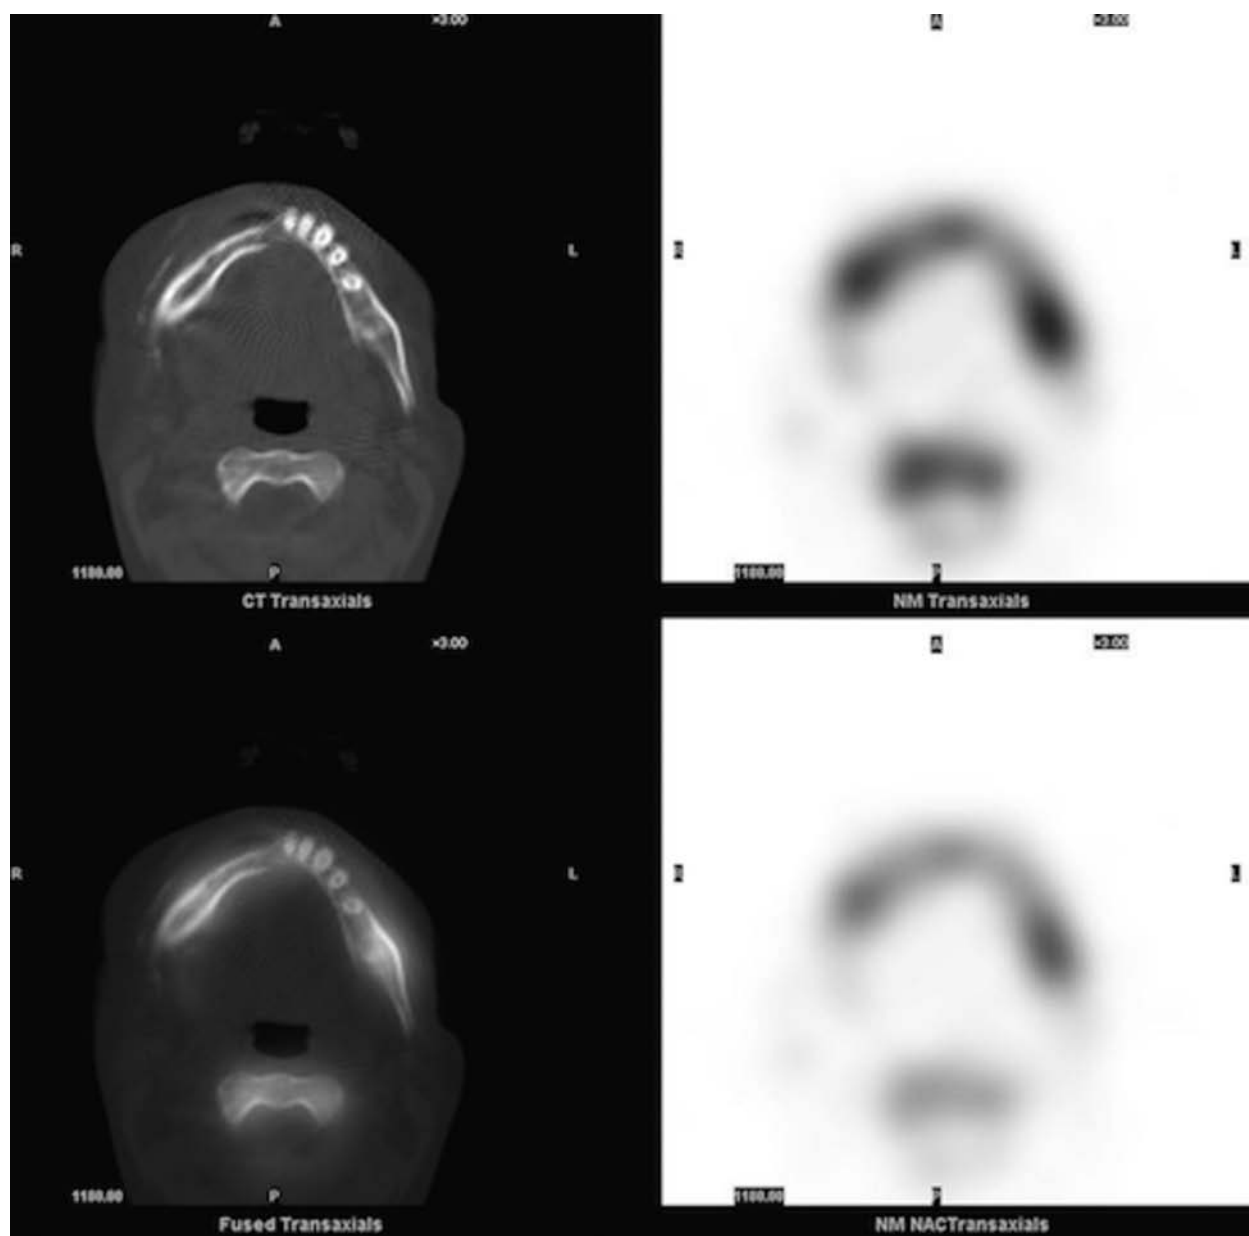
SPECT-CT performed at postoperative month 6, showing osteogenic activity of the BAS used for mandibular reconstruction. BAS, bone allograft segment; SPECT, single-photon emission computed tomography-computed tomography.
